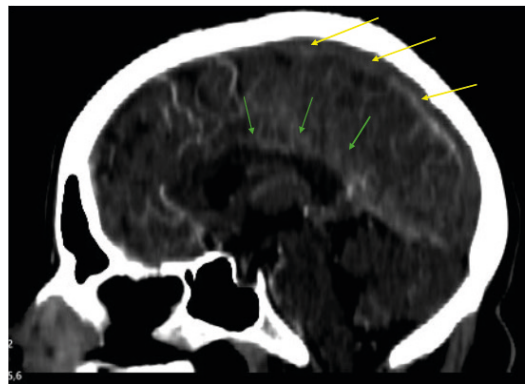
Computed Tomography Angiography of the Skull showing: Filling failure in the superior sagittal sinus (yellow arrow) and inferior sagittal sinus (green arrow).
